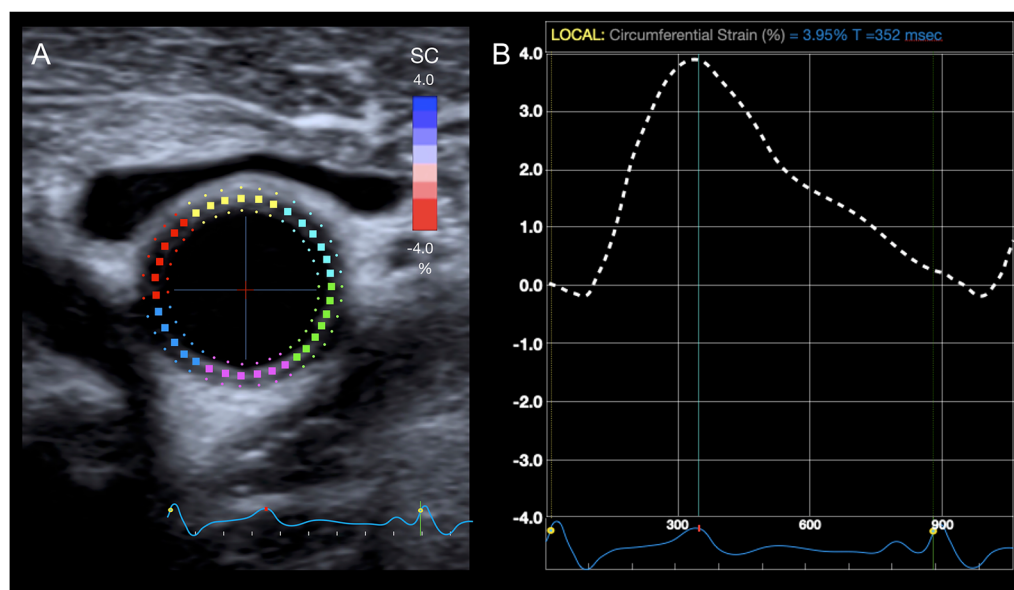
Speckle tracking strain imaging of the CCA. A Short-axis ultrasonography of the CCA, where the region of interest is outlined by a color-coded circumferential strain map. Each of the six segments included in the strain analysis is represented with a different color. B The strain
